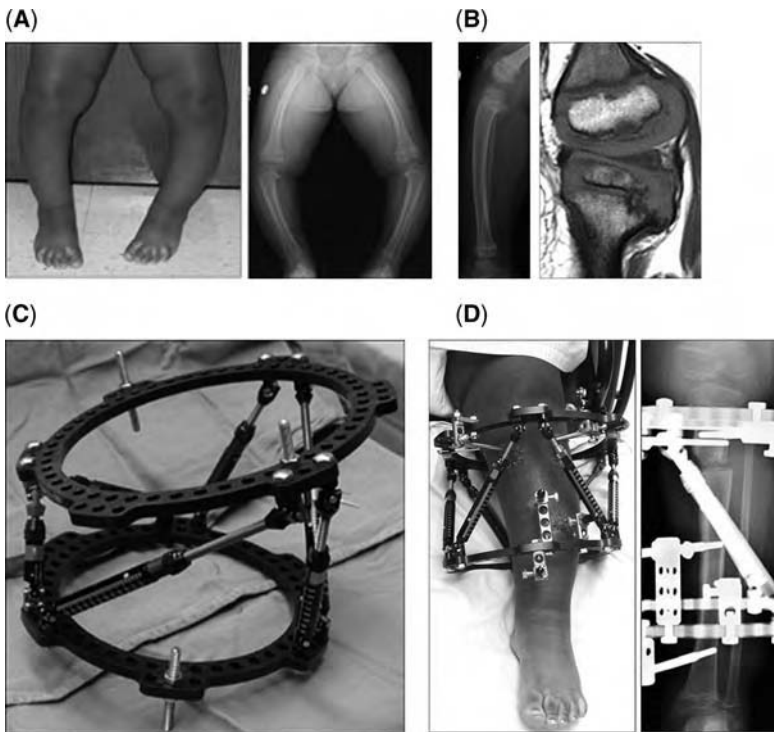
(A) Clinical photo and standing radiograph of a three-year-old female with bilateral early onset Blount's disease. (B) Lateral radiograph and sagittal magnetic resonance imaging of the same patient demonstrating proximal tibial procurvatum and changes in the posterior portion of the medial tibial growth plate. (C) Preconstructed external fixator for correction of varus, procurvatum, and internal tibial torsion of left leg. (D) Clinical photo and radiograph following gradual correction of the triplanar tibial deformity.
